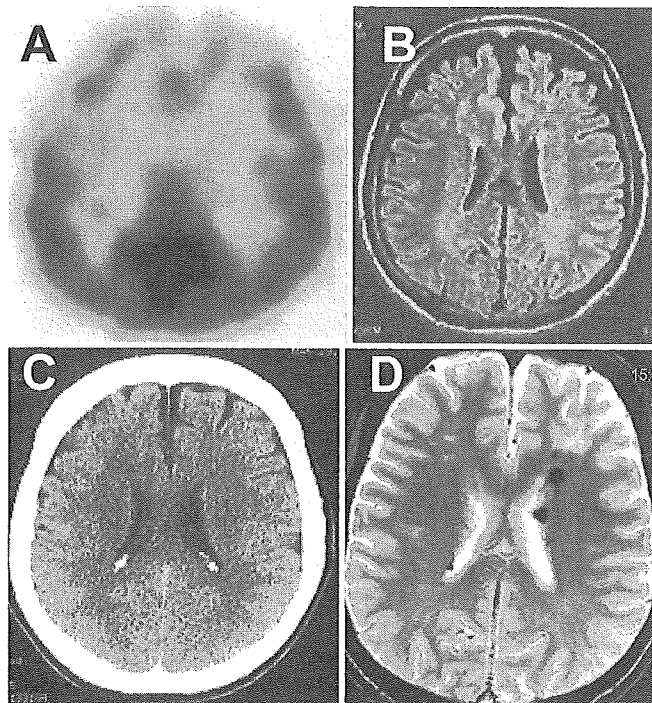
Case 5. A: An ^{123}I -IMP SPECT scan revealing decreased rCBF in the bilateral frontal lobes. B: A FLAIR 1.5-tesla MR image demonstrating mild ischemic lesions in the deep white matter of the frontal lobes. C: A CT scan displaying no hemorrhagic lesion. D: A T_2^* -weighted 3-tesla MR image revealing multiple MBs in the periventricular regions.
